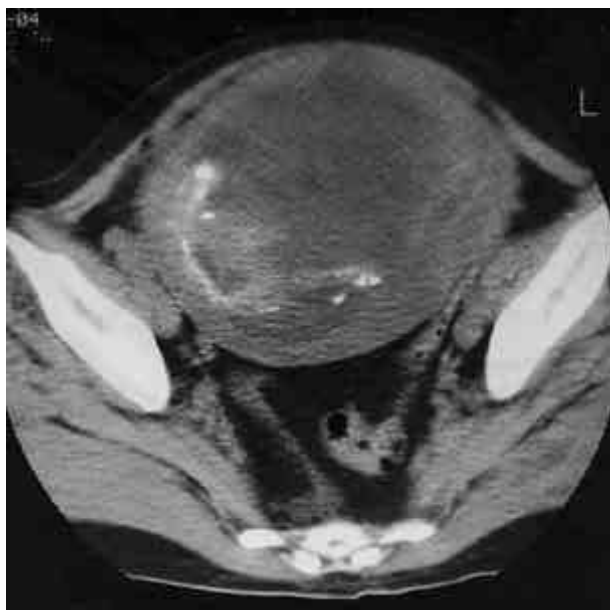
CT shows a huge diffuse hyalinized mass with linear and nodular calcifications.
